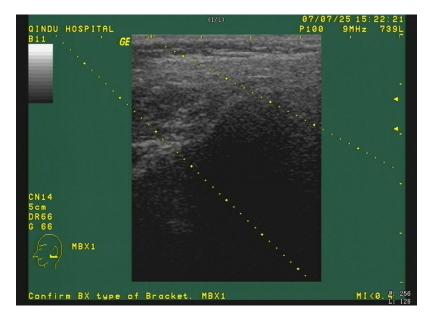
The ultrasonography image showed the lesion disappeared completely on follow-up visit nearly 10 months later (Jul. 25, 2007).
